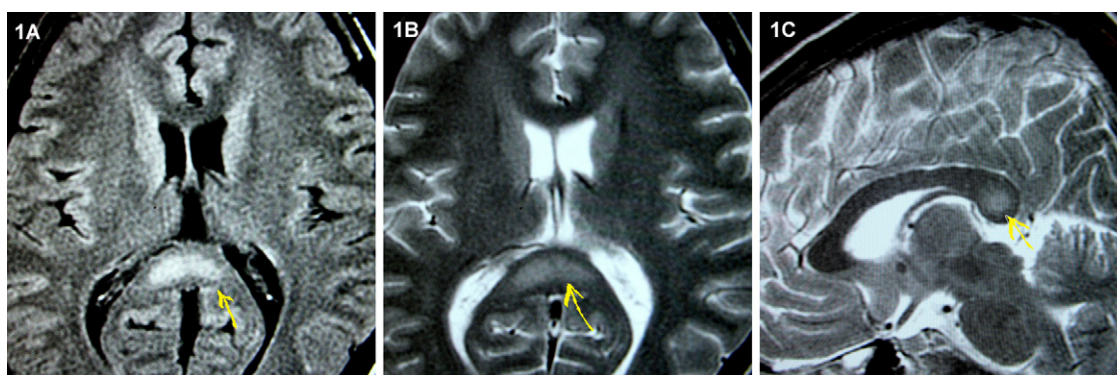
MRI of the brain on admission. (A) FLAIR, (B) axial T2-weighted, and (C) sagittal T2-weighted images showing a semilunar hyperintense lesion (yellow arrow) in the central portion of the splenium of the corpus callosum.
